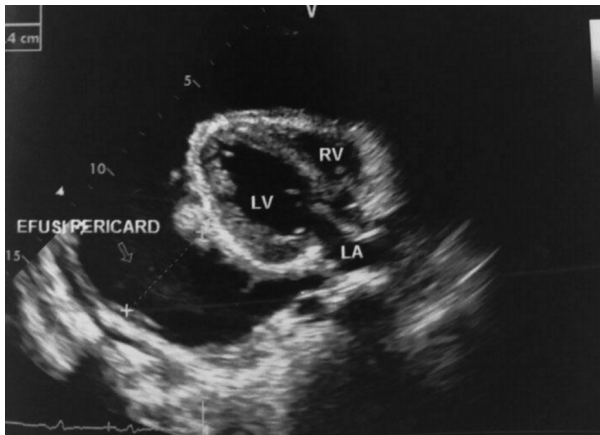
Case 2. Echocardiography at the district hospital revealed massive pericardial effusion
